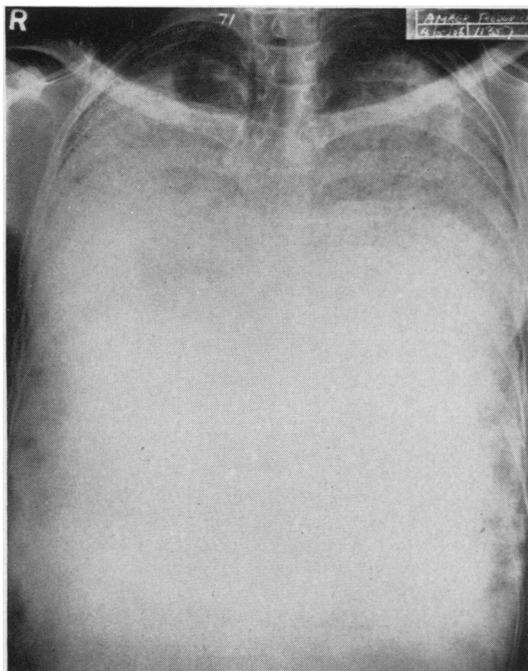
Chest radiograph by standard technique.
